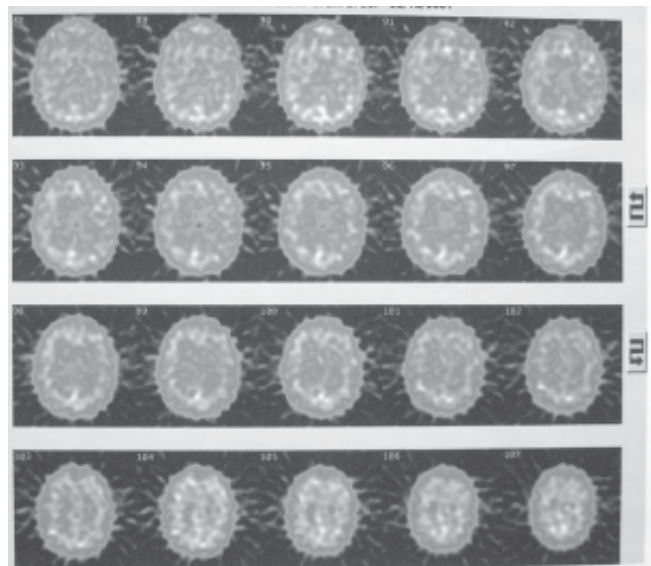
Brain SPECT: Done with Tc-99-M-HMPAO showing heterogenous and general hypoperfusion in grey matter of Case 1.
